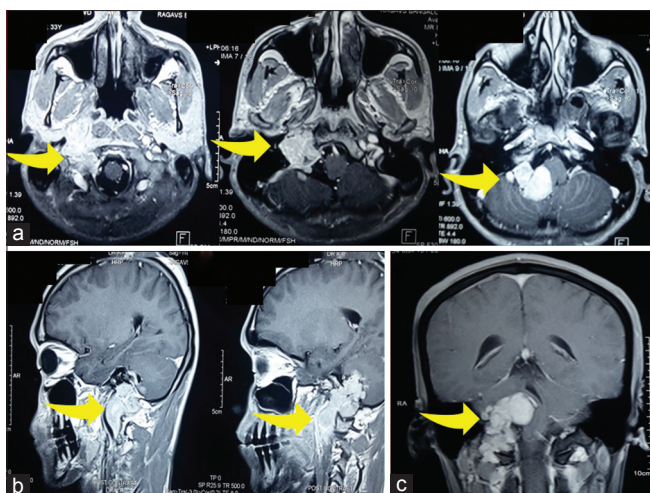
Preoperative images of patient 2: (a-c) Contrast-enhanced magnetic resonance imaging axial, sagittal, and coronal images, respectively, showing tumor in the right cerebellopontine angle with extracranial extension (arrows)
